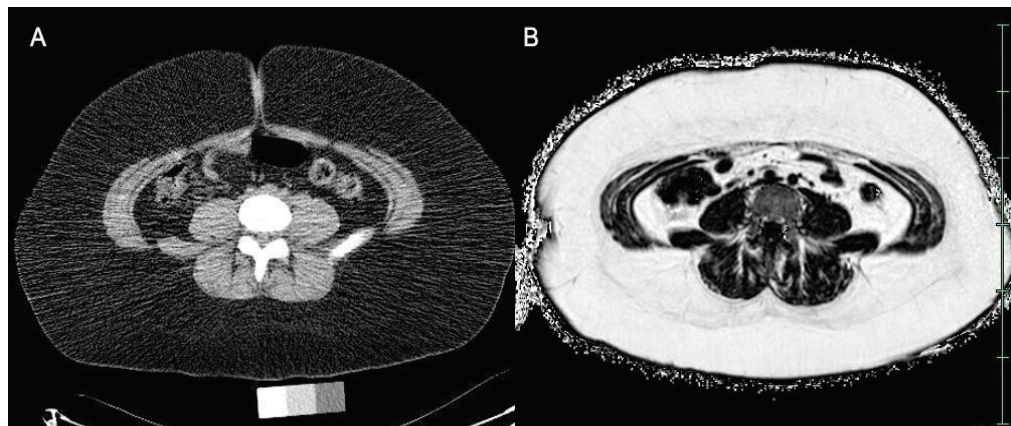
Abdominal adipose tissue imaging of a female adolescent with classical congenital adrenal hyperplasia to quantify visceral and subcutaneous adipose tissue. Single-slice images in the axial view, at the L4 vertebra. A) Single-slice computed tomography image was acquired at 12 years of age, prior to the initiation of topiramate treatment. B) Magnetic resonance image was acquired at 21 years of age, four years following the initiation of topiramate treatment
